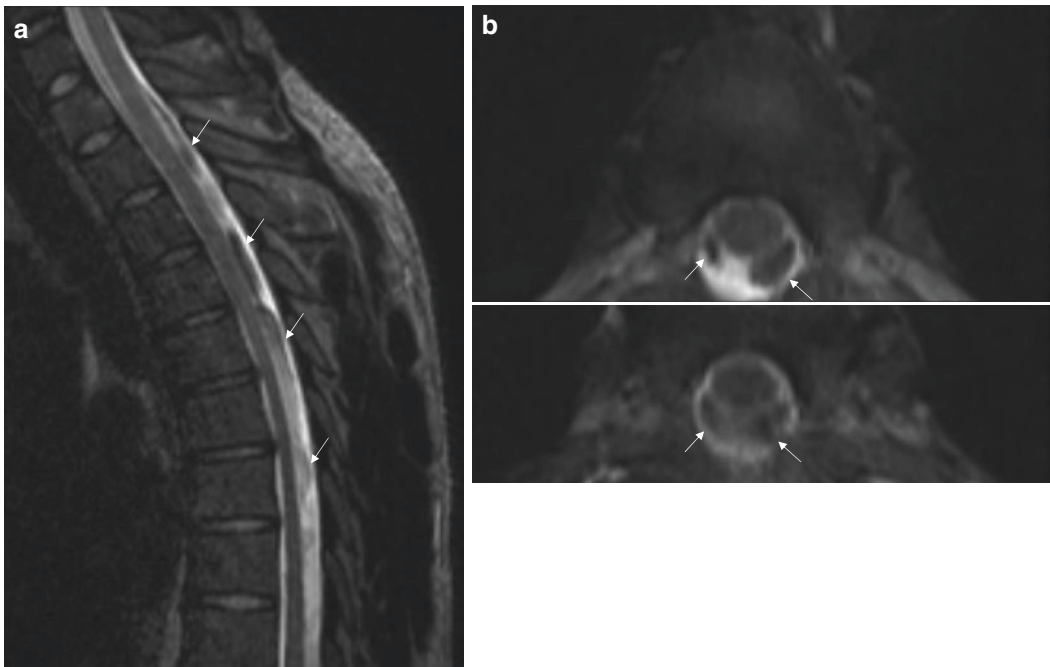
(a) Sagittal T2- and (b) axial T2-weighted images of the thoracic spine demonstrate artifactual CSF flow voids in the dorsal subarachnoid space (white arrows). It is important not to mistake this for subdural or subarachnoid hemorrhage
